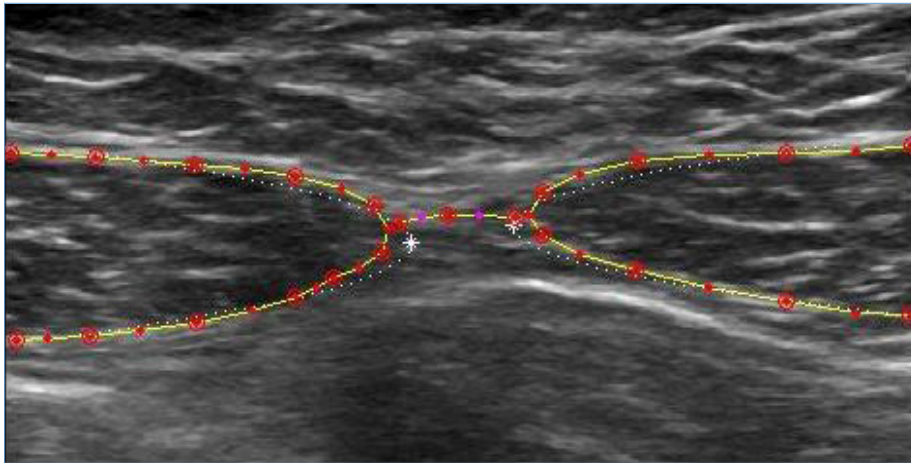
Rectus abdominis ultrasound image. Interpolated points using an algorithm according to a parabola-shape like curve (white points); parabola inflection point (white asterisk) suggesting the end-points for IRD measurement on the medial margin of both RA.
